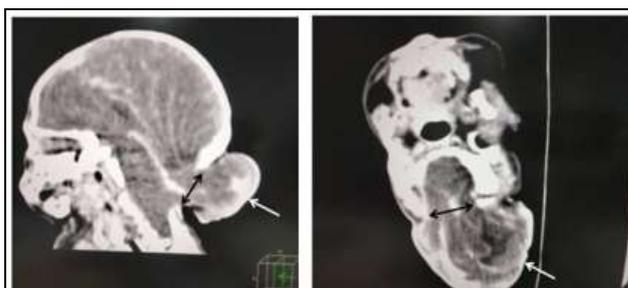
Contrast Enhanced Sagittal, and Axial CT Sections of the Brain Showing Defect in Occipital Bone (Black Arrow) with Herniation of Cerebellum and Bilateral Occipital Lobes (White Arrow) Through the Defect - Occipital Encephalocele
